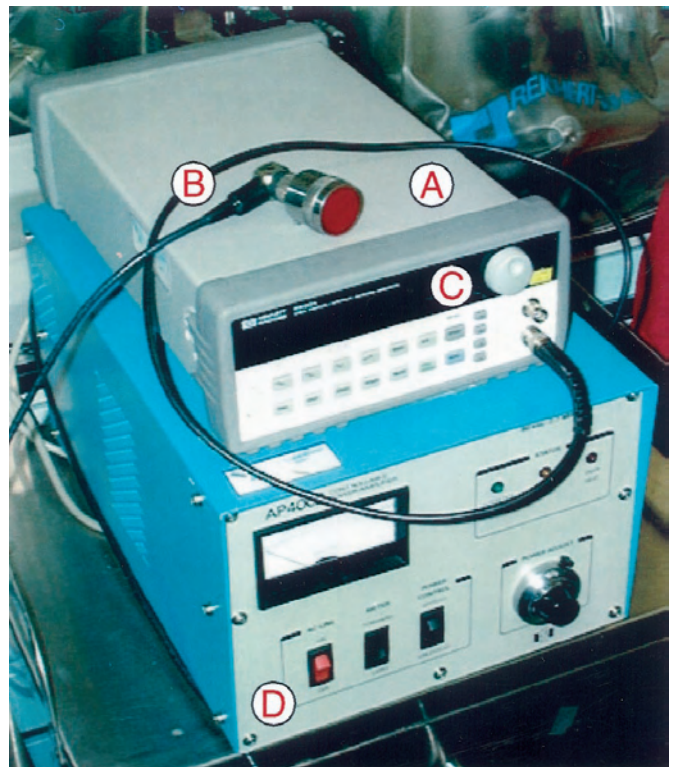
Ultrasound equipment. A, transducer; B, waterproof B&C cable; C, function generator; D, amplifier. The red part of the transducer measures 2.54 cm in diameter and is the source of a spatially uniform acoustic field.
